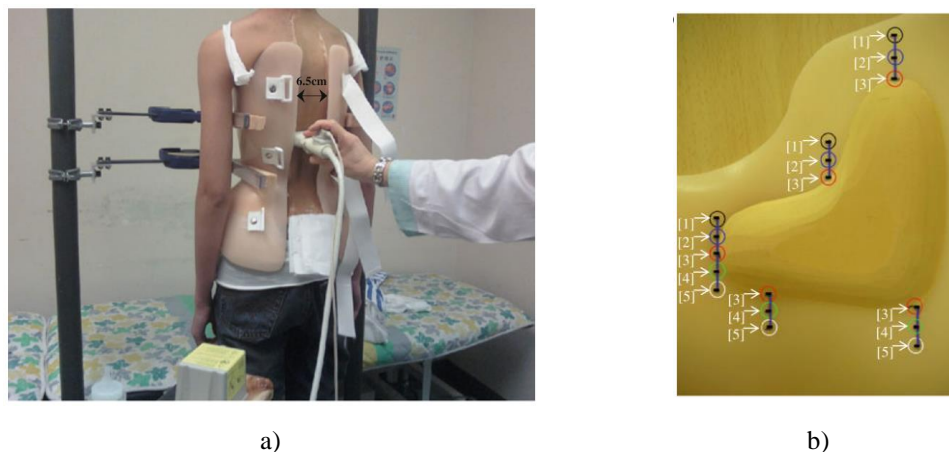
a) In-brace ultrasound scanning, and b) the locations for corrective pad (Li *et al.*, 2010, Li *et al.*, 2012)
